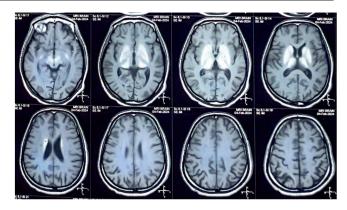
2 - MRI brain of Mr D showing symmetrical calcifications along bilateral basal ganglia, thalamii, midbrain, pons and cerebellum
